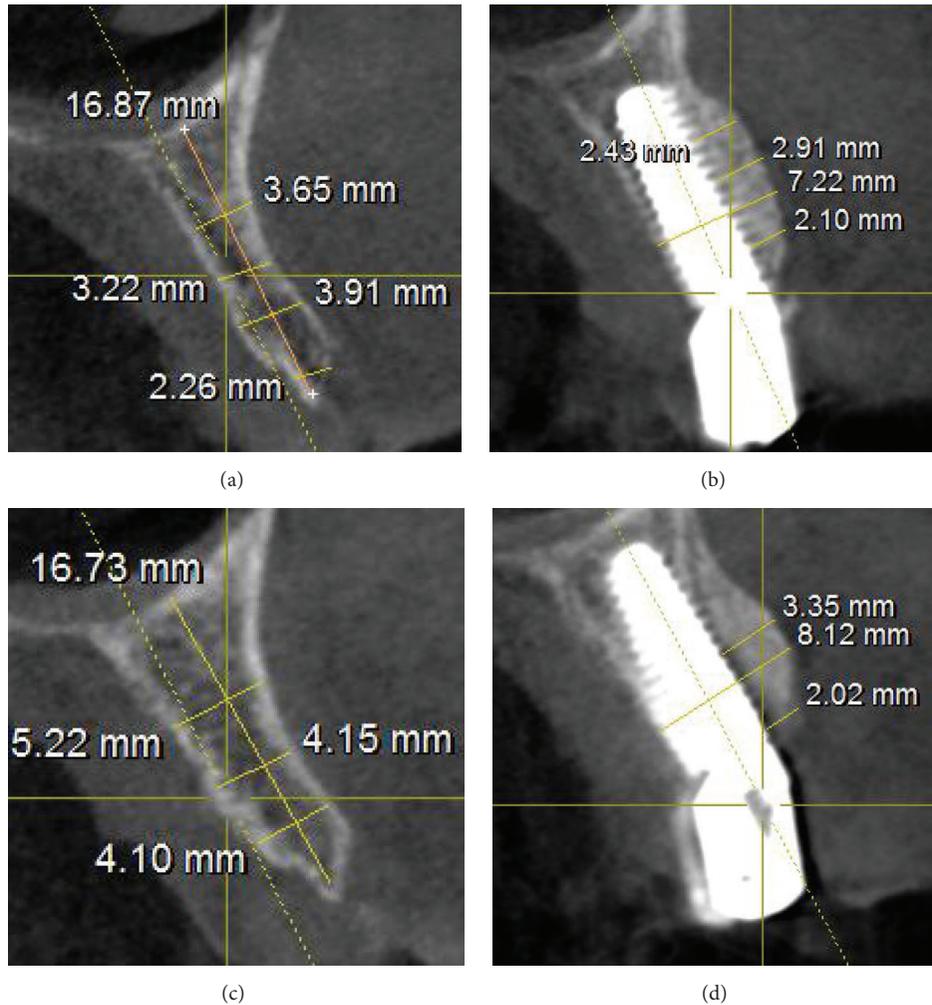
Cone beam computed tomography (CBCT) scans of the sites before surgery and after removal of the titanium meshes, three months later. (a) Right side: preoperative situation with a very thin residual alveolar ridge; (b) right side: the radiographic situation three months after surgery; (c) left side: preoperative situation with a thin residual alveolar ridge; (d) left side: the radiography three months after surgery.
